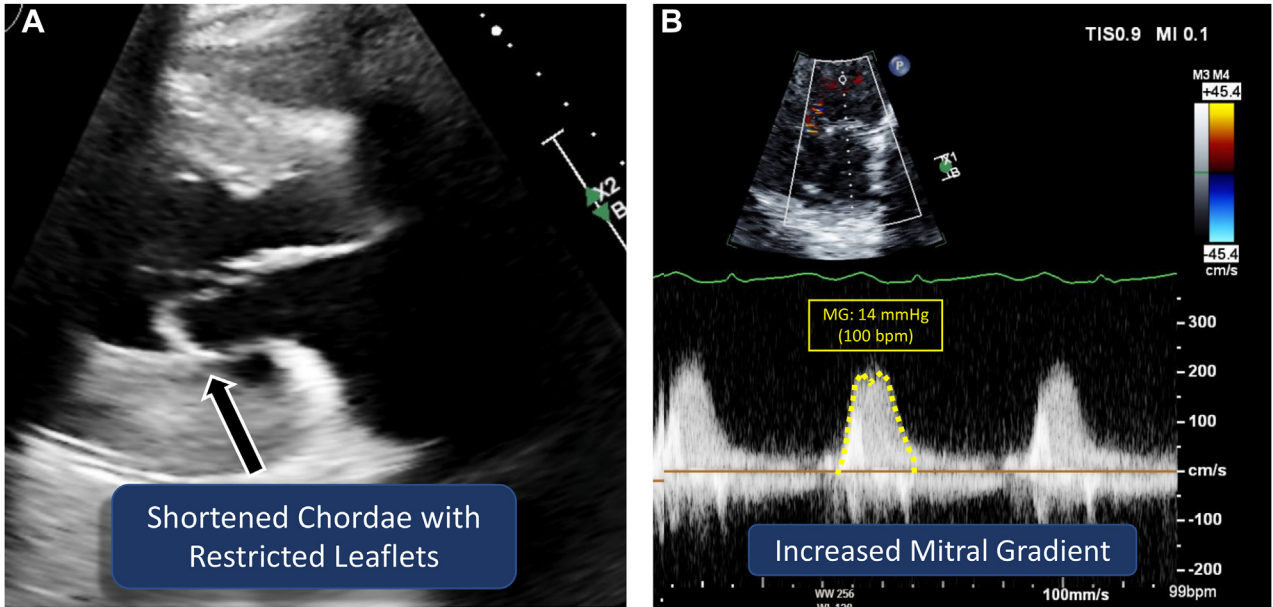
(A) Two-dimensional TTE, parasternal long-axis view, diastolic phase, demonstrates shortened chordae with restricted and domed mitral leaflets. (B) Two-dimensional TTE, apical 4-chamber view, continuous-wave Doppler spectrum, demonstrates severe MS with a mean diastolic pressure gradient of 14 mm Hg (at HR 100 bpm).
